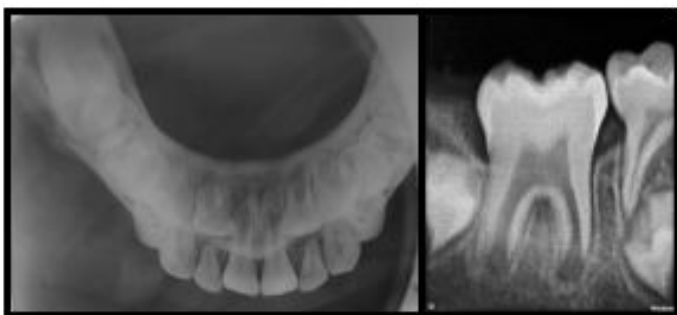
Investigations- a. Occlusal radiograph, b. RVG of 46.
